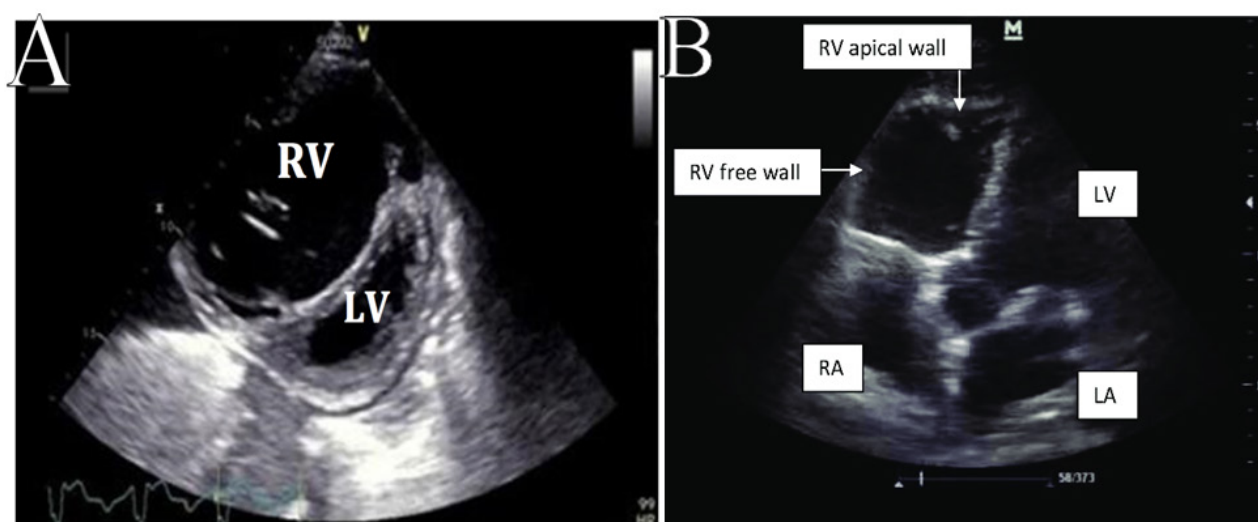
Images of D-sign and McConnell's sign in PSSA and A4 view. A: D-sign in terms of PSSA view B: McConnell's sign in terms of A4 view RV: right ventricle, LV: left ventricle, RA: right atrium, LA: left atrium, A4: apical four chamber, PSSA: parasternal short axis
